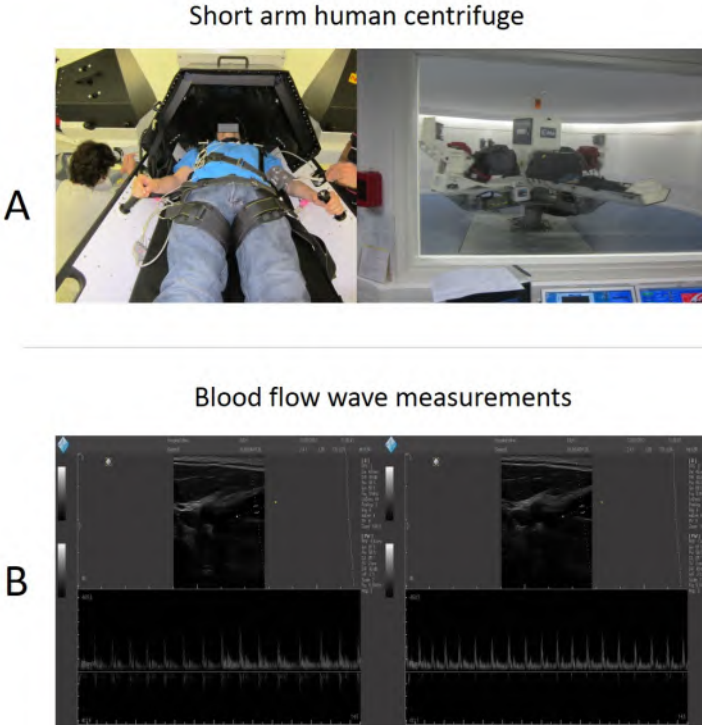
CPMM test campaign in the short arm human centrifuge. A) Photos of the short arm centrifuge including preparation of the volunteer. B) Spectral PW Doppler images of the carotid artery during acceleration (left) and deceleration (right) phases of the protocol. CPMM: continuous physiological and medical monitoring.
